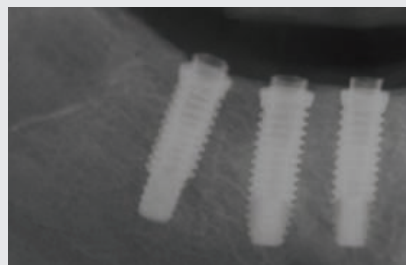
Radiograph of implants showing correct depth and placement.
